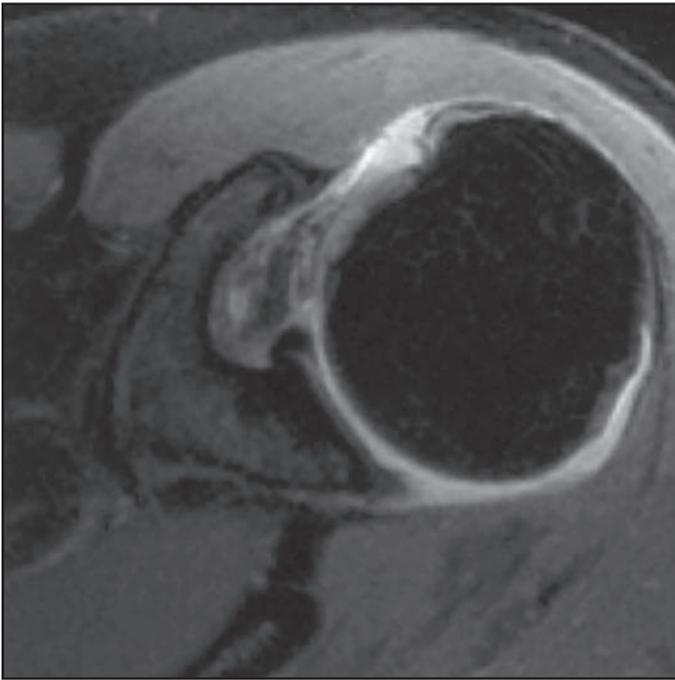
In this axial slice MRI, note the enlargement of the biceps tendon as it courses over the humeral head to its proximal attachment. Increased signal intensity surrounding the tendon, consistent with inflammation of the synovial sheath is also present.
